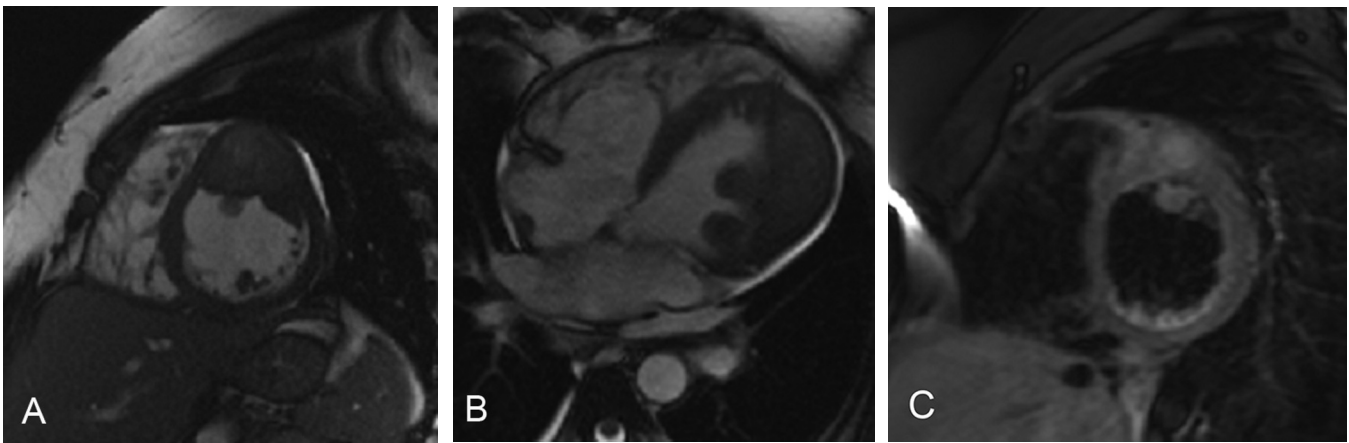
46-year-old female with spindle-cell sarcoma of the heart. Short-axis (A) and 4-chamber (B) bright-blood MRI images showed a mass in the left ventricle with predominantly hyperintense T2 signal. A fat-suppressed, postcontrast, T1-weighted, short-axis image (C) showed heterogeneous enhancement in the mass lesion.
